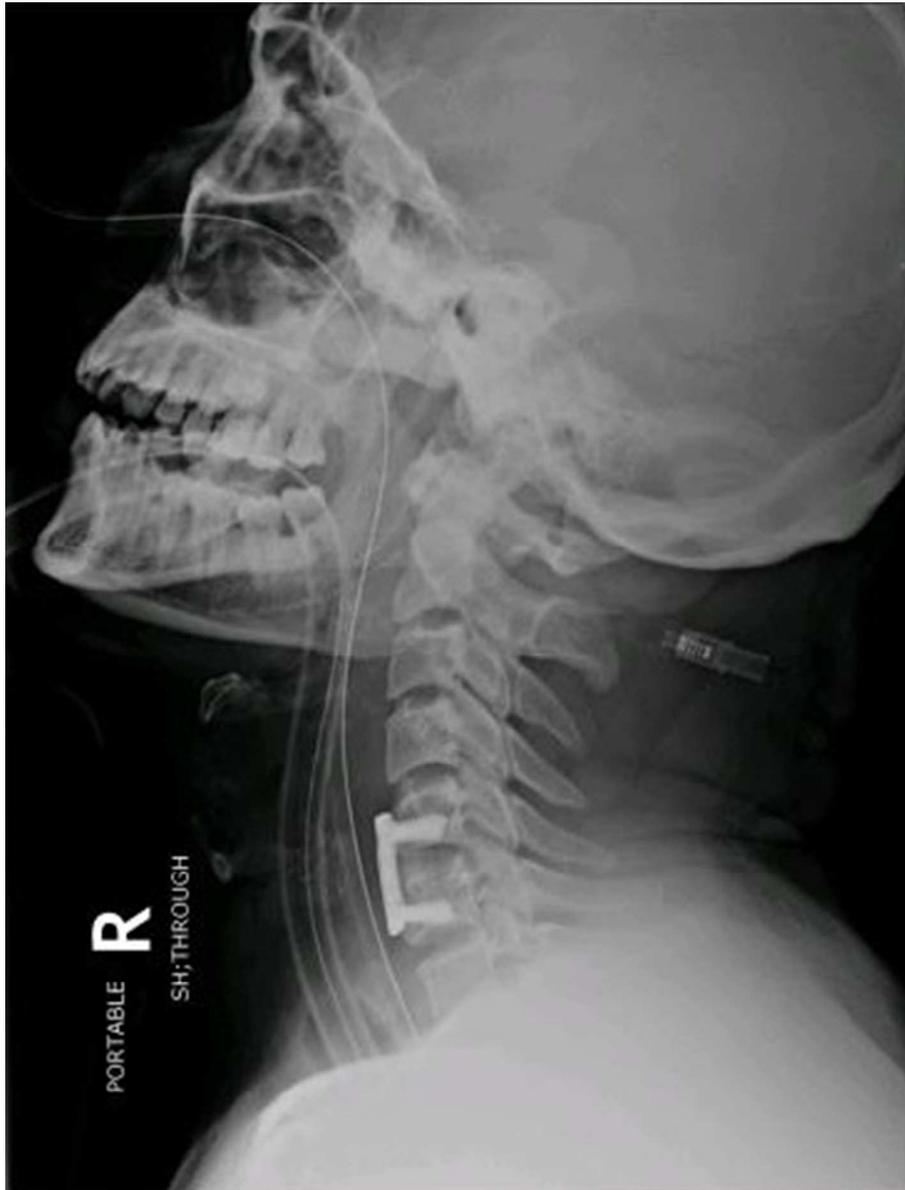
X-ray cervical spine lateral view, demonstrating bone graft and plate in place without any migration in the spinal canal.
